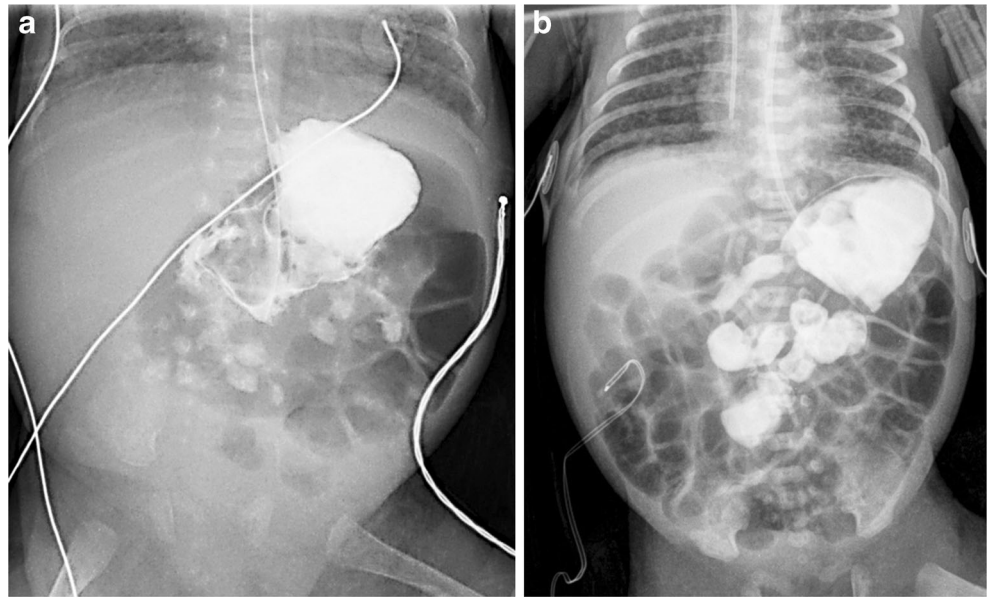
Image in a 3-day-old boy, 27 weeks' gestational age. A 1-min radiograph from a bedside UGI study demonstrates multiple dilated loops of small bowel distorting the position of the DJJ. The location of the DJJ could not be accurately determined
